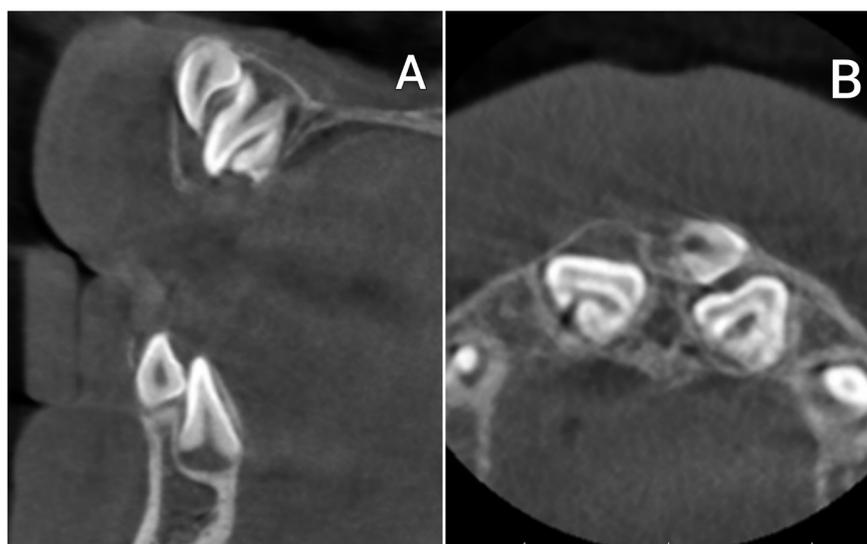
The CBCT images taken to examine the morphology of the patient's teeth are shown. Sagittal(A) CBCT sections demonstrating maxillary impacted primary central incisors and impacted permanent central incisors with talon cusps, and mandible impacted primary incisors and impacted permanent incisors. Axial(B) CBCT sections demonstrating maxillary impacted primary incisor, impacted permanent central incisors with talon cusps and impacted primary lateral incisors.
